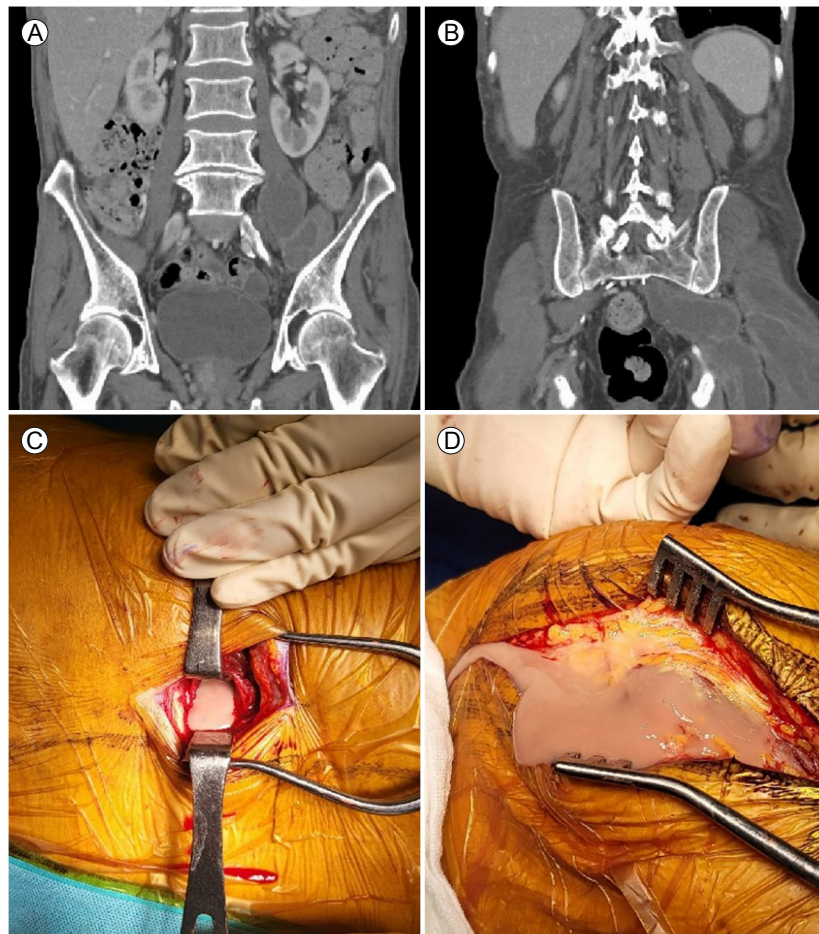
Radiological and intraoperative findings of the multifocal intramuscular abscess. (A) Abdominopelvic computed tomography reveals multiple peripheral enhancing fluid collections involving the left psoas and iliacus muscles. (B) Abdominopelvic computed tomography reveals multiple peripheral enhancing fluid collections involving the left gluteus maximus and piriformis. (C, D) A skin incision was made from 5 cm distal to the posterior superior iliac spine to 5 cm distal to the greater trochanter, and huge amounts of brownish pus gushed from the gluteus maximus.
